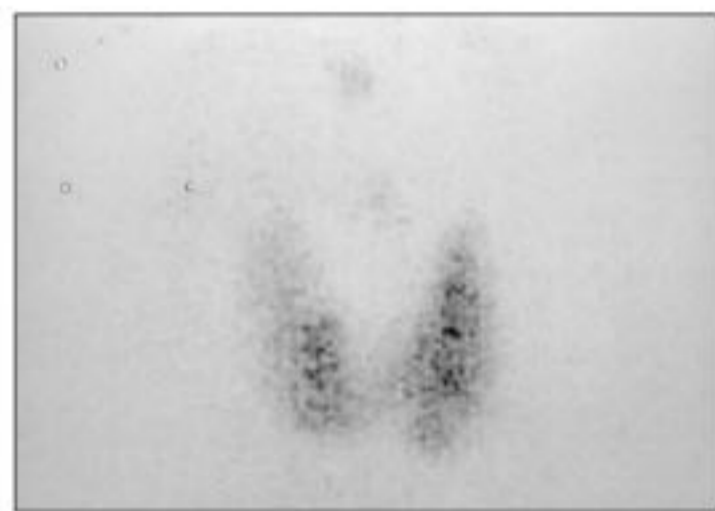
Thyroid scintigraphy: Thyroid gland was enlarged, its activity distribution was heterogeneous and right lobe's upper part was hypoactive
